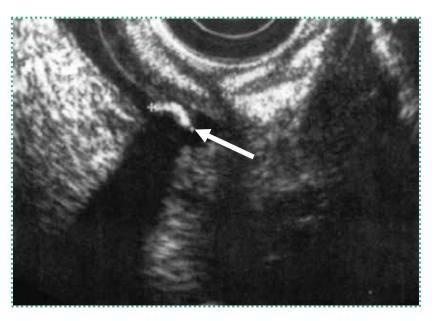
EUS image depicting an echogenic rounded focus with acoustic shadows (posterior attenuation of ultrasound waves) within the bile duct, compatible with a stone (arrow).
